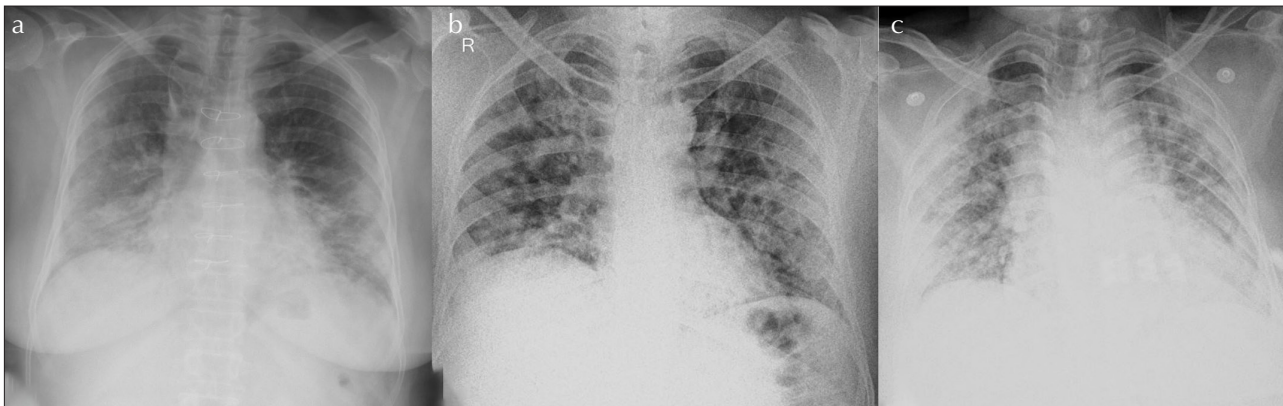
a-c. (a) Chest X-ray (CXR) showing consolidation with ground-glass opacity (GGO) involving bilateral middle and lower zones; total CXR score is 8. (b) CXR showing consolidation with reticulations involving peripheral as well as central lung field of bilateral lower, mid, and upper zones; total score is 9. (c) CXR showing consolidation with GGO of bilateral lower, mid, and upper zones involving peripheral lung field; the total score is 10
